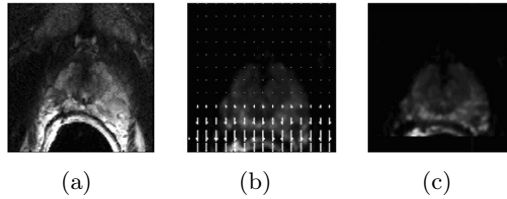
a) Prostate on T2 image. b) Deformation field superimposed on DWI. c) Deformation field applied on DWI.*
